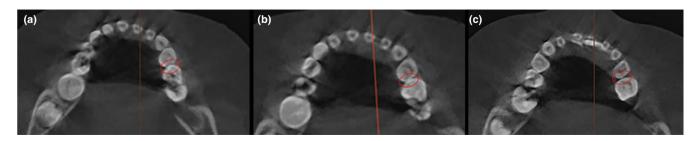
Scoring of the maxillary right molar contact area at 3 levels on the CBCT image. A, Score 3 at the occlusal third (S type); B, score 1 at the middle third (X type); C, and score 0 at the cervical third (O type), respectively
